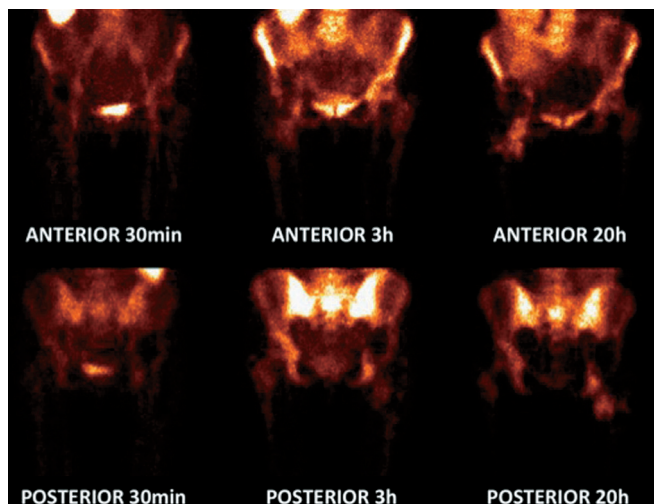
A case of suspected PJI studied with ^{99m}Tc -HMPAO-WBC. Images were acquired in antero-posterior at 30 min, 3 h and 20 h with acquisition time corrected for isotope decay and displayed in absolute counts. The presence of osteomyelitis with soft tissue involvement is clearly defined in 20 h images without the need of SPECT/CT. Hybrid images, however, can add useful information on the extent of the infection.
